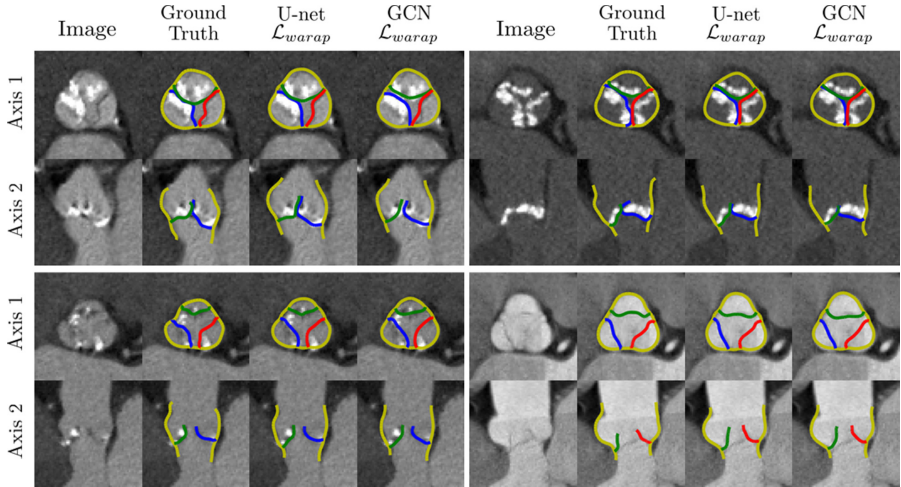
CT images and predicted meshes at 2 orthogonal viewing planes. Each block of 8 images is a different test set patient. Y: aortic wall and R, G, B: valve leaflets
